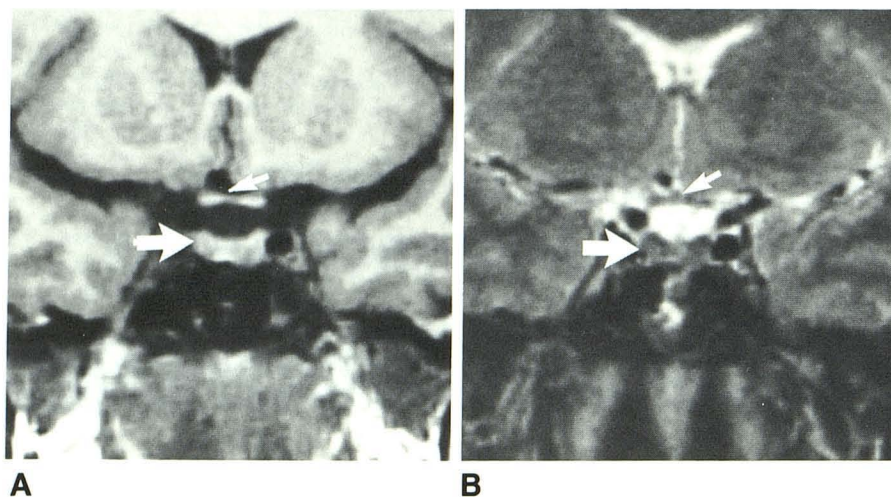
Coronal MR images of pituitary gland in normal volunteer. A, Short TR image (400 msec TR, 14 msec TE). Pituitary gland (*large arrow*) and optic chiasm (*small arrow*) have homogeneous signal intensity intermediate between that of fat (white) and CSF (black). B, Long TR image (2000 msec TR, 100 msec TE). Pituitary gland (*large arrow*) has uniform signal. Optic chiasm (*small arrow*) is more difficult to distinguish.
